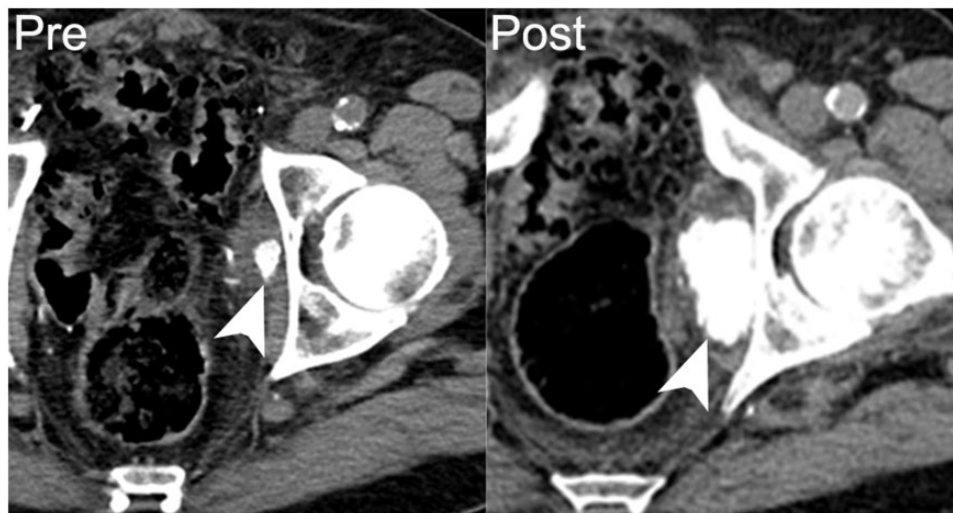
A 75-year-old man with recurrent papillary transitional cell carcinoma of the bladder. Axial nonenhanced CT image shows a metastasis in the left obturator internus, with dense calcification (arrowhead on left). Following 9 months of chemotherapy the patient’s disease progressed, with increasing size and calcification of the left obturator metastasis (arrowhead on right).
